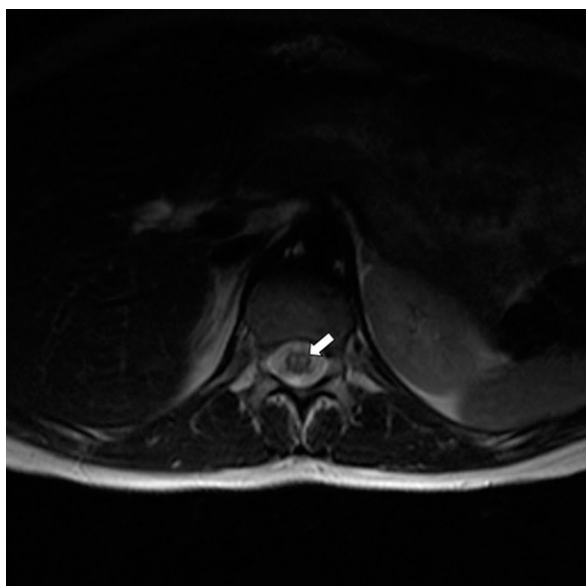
Tranverse view of the spinal cord with a T2-weighted image showing abnormal T2 signals localized in the bilateral anterior horn cells (arrow).
